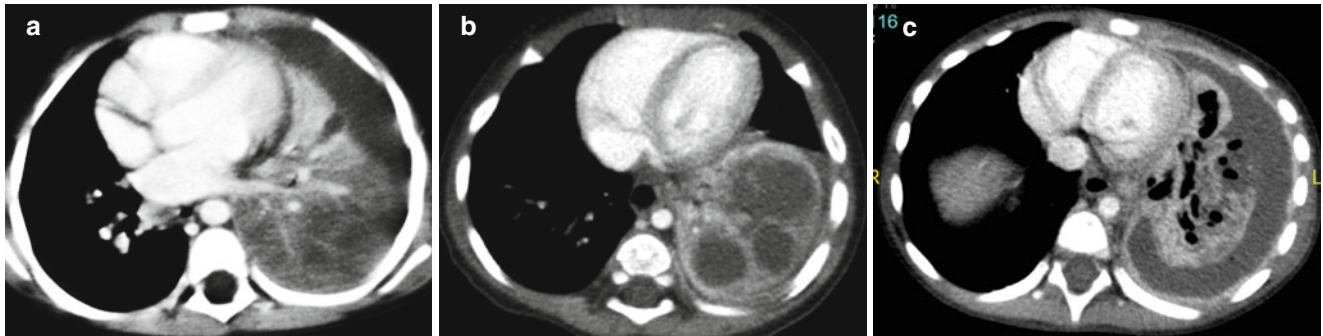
Necrotizing pneumonia on CT. Left lower lobe consolidation showing diminished perfusion at the posterior region (a). Evolution of lung ischemia with development of multiple fluid-filled cavities (b).
